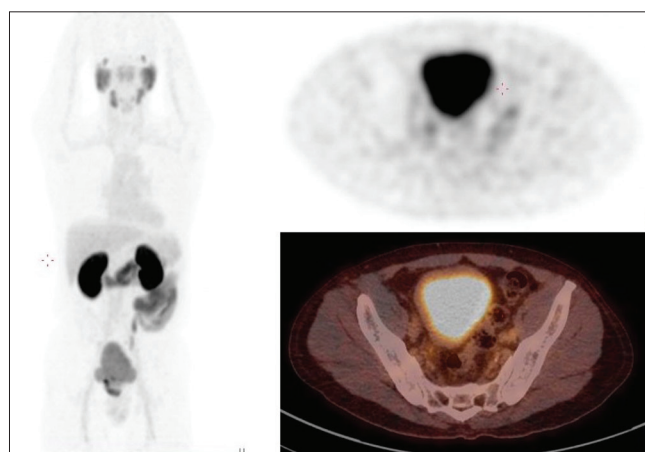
<sup>68</sup>Ga-PSMA PET-CT images show no evidence of skeletal metastasis
